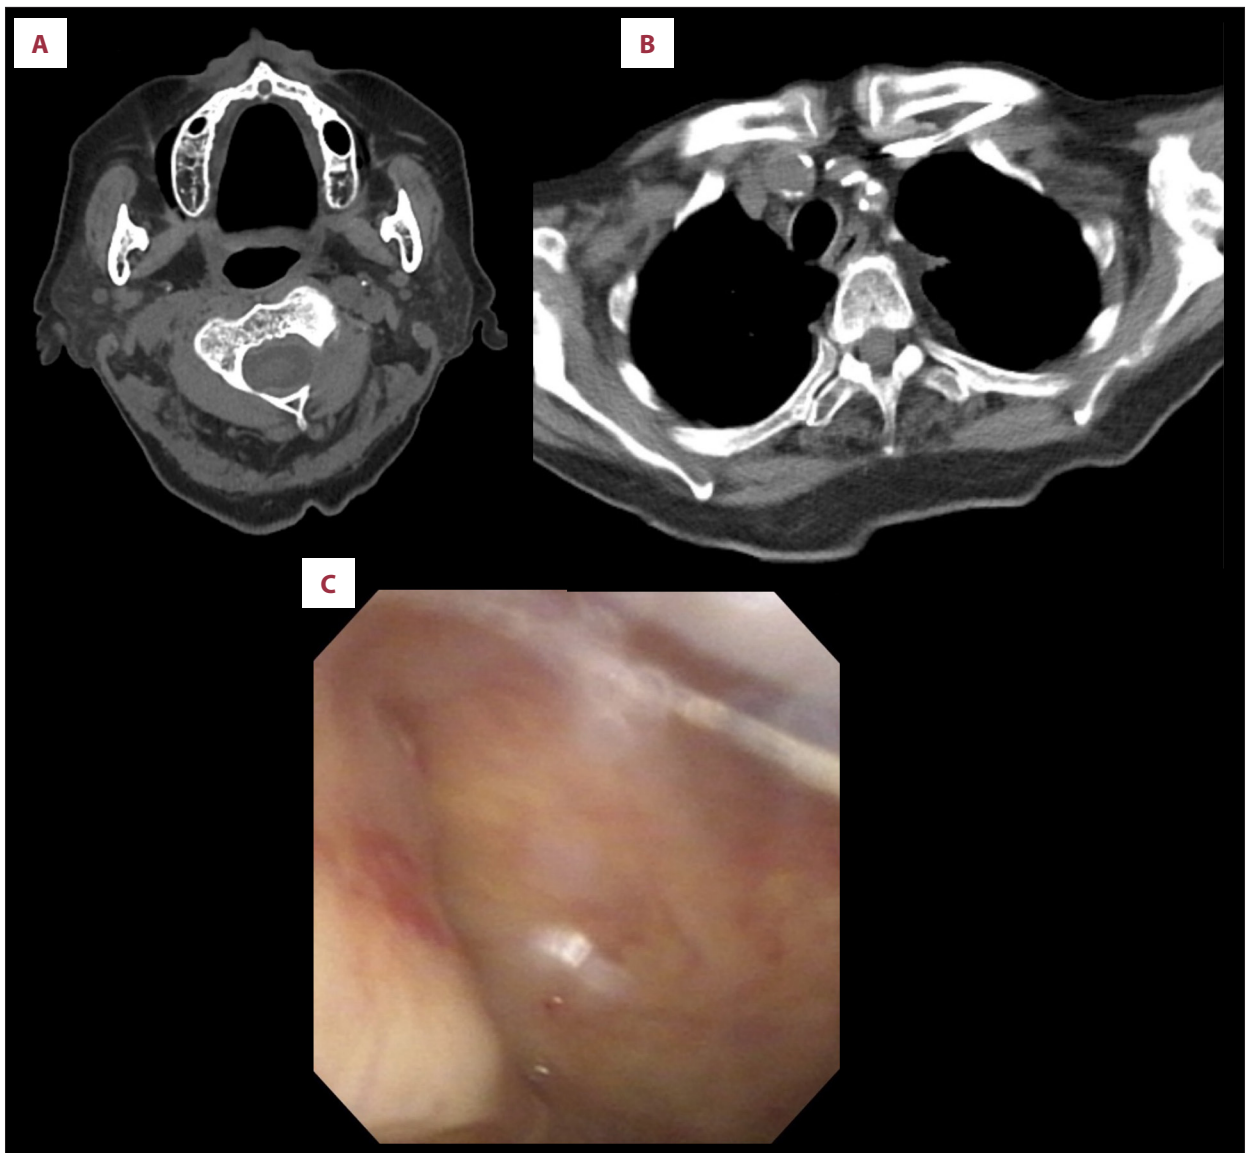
(A) CT scan shows cervical emphysema had disappeared. (B) CT scan shows that the pneumomediastinum had disappeared. (C) Nasopharyngeal endoscopy shows recovery of the nasopharyngeal mucosa.
